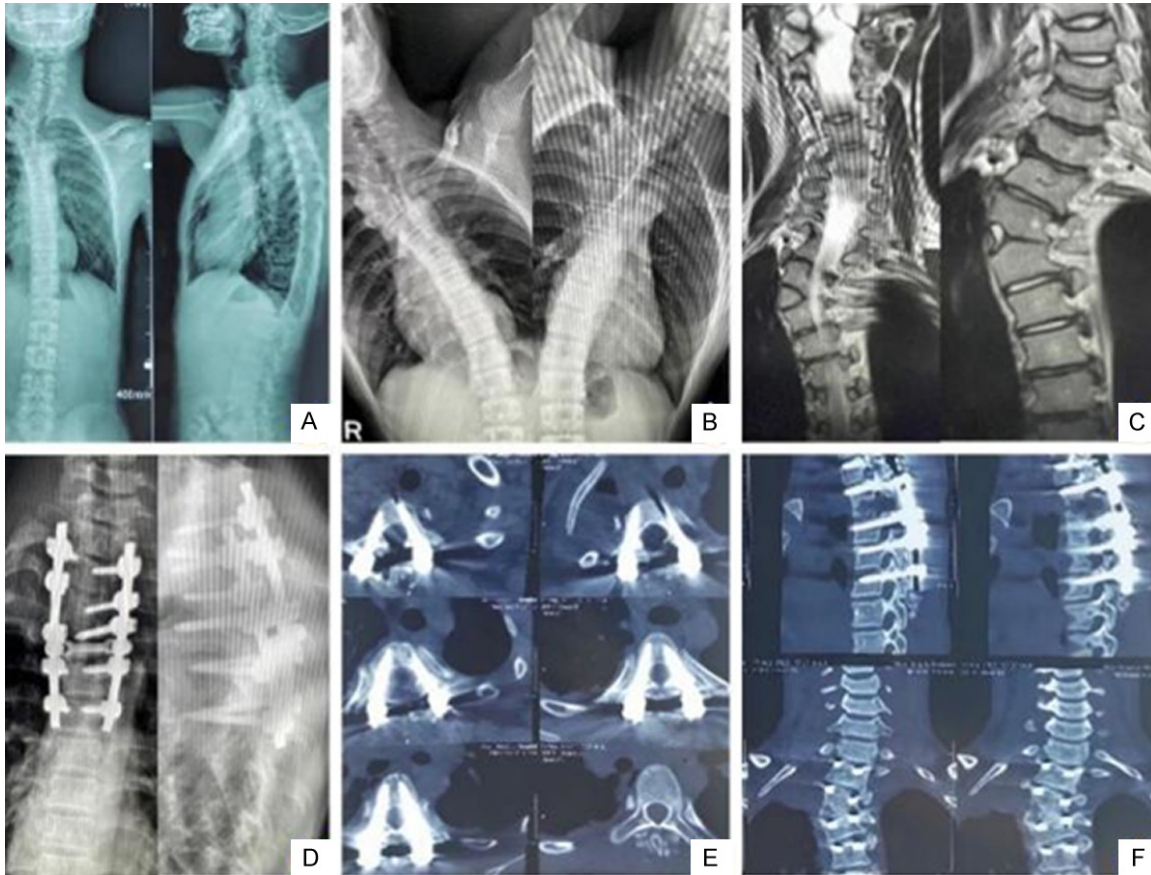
Typical case. Male, 11 years old, with congenital scoliosis. A. The patient presented with a thoracic hemivertebral spinal deformity. B. Preoperative full spinal hyperextension and hyperflexion position. C. Preoperative MRI suggests hemivertebral deformity. D. Postoperative frontal and lateral DR. E, F. Postoperative CT. The patient recovered well with no significant complications.
